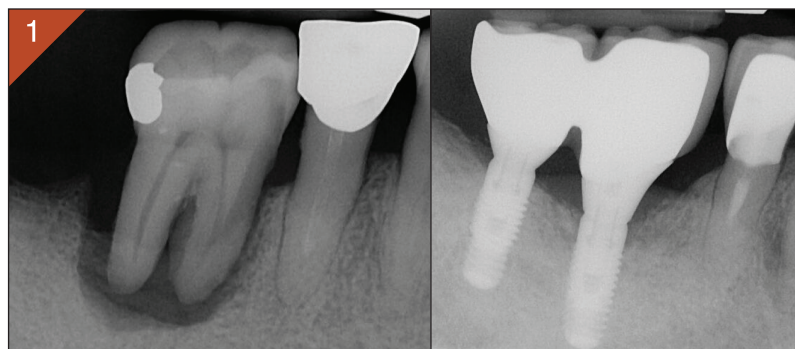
a) Pre-operative radiograph b) 4 years post-operative radiograph
